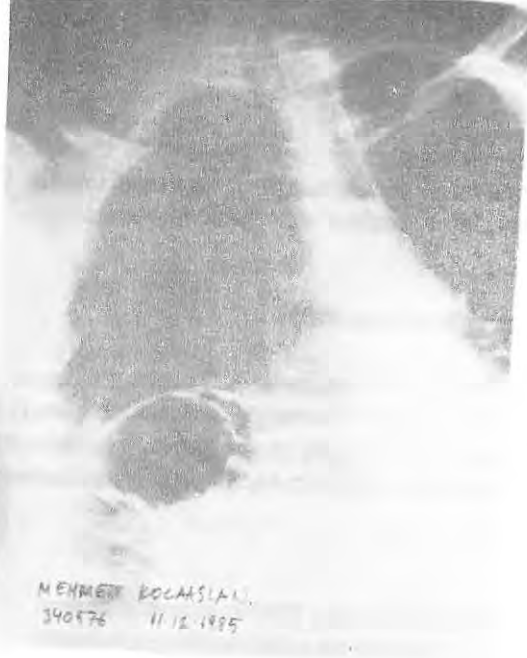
Chest radiograph shows three characteristic radiologic features of symptomatic interposition:
